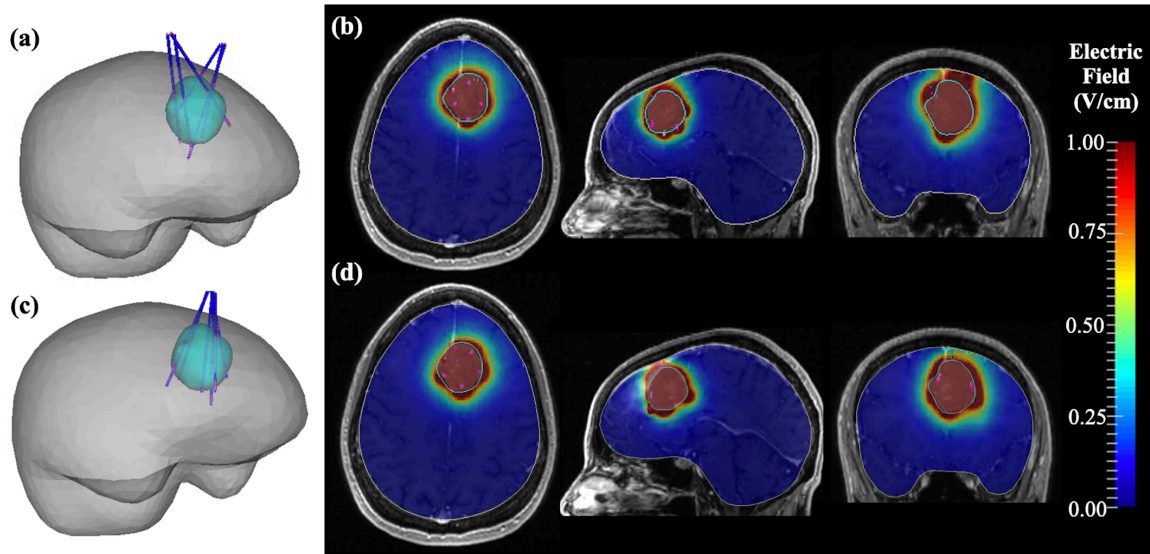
Results of electric field optimization for the (a) dual entry six-electrode human model with electrode location results displayed as the 3D geometry of brain (grey), tumour (cyan), electrodes (blue) and active contacts (magenta). The resulting electric fields (b) are displayed on selected axial, sagittal, and coronal cross sections superimposed on the MRI. Further numerical results of optimal phase shift, voltage amplitude, and electrode trajectories can be found in Appendix D (Figure D.2). Results of electric field optimization for the (c) six-electrode single entry human model with 3D geometry and (d) resulting electric fields displayed on selected axial, sagittal and coronal cross sections superimposed on the MRI. Further numerical results of optimal phase shift, voltage amplitude, and electrode trajectories can be found in Appendix D (Figure D.3).
